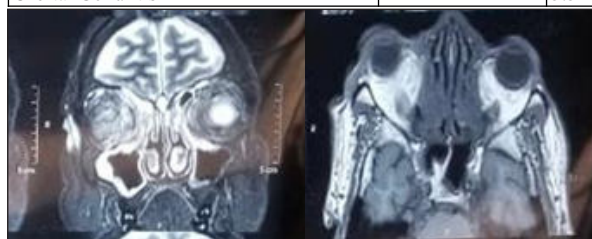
MRI(Brain+Orbit+PNS) Showing Extensive Fat Stranding In Right Orbit In Coronal And Axial Section Respectively.
